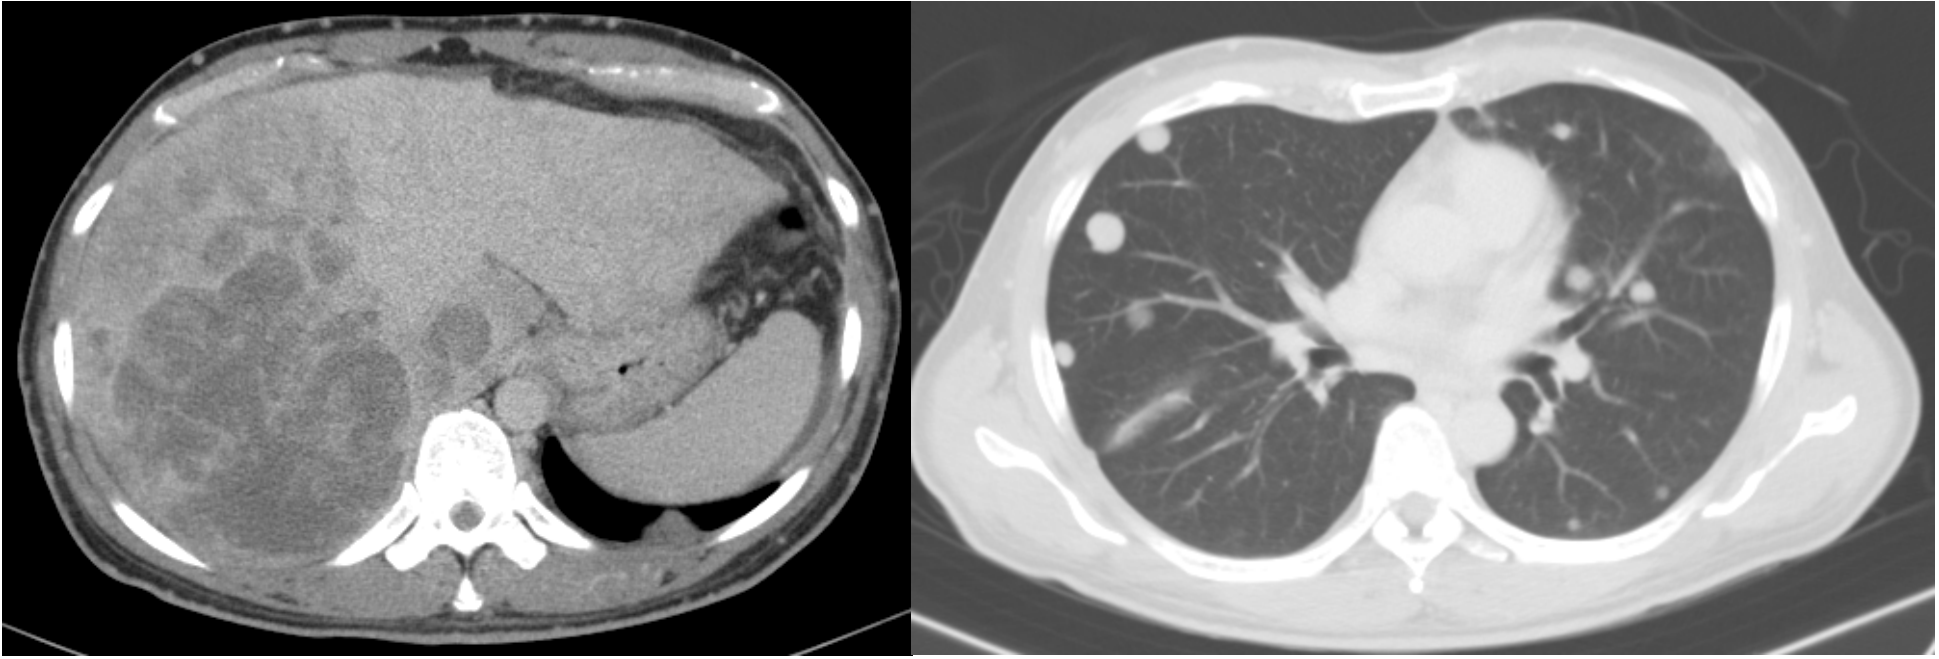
2021/09/29 CT scan : tumor progression after 3 cycles AA therapy.
